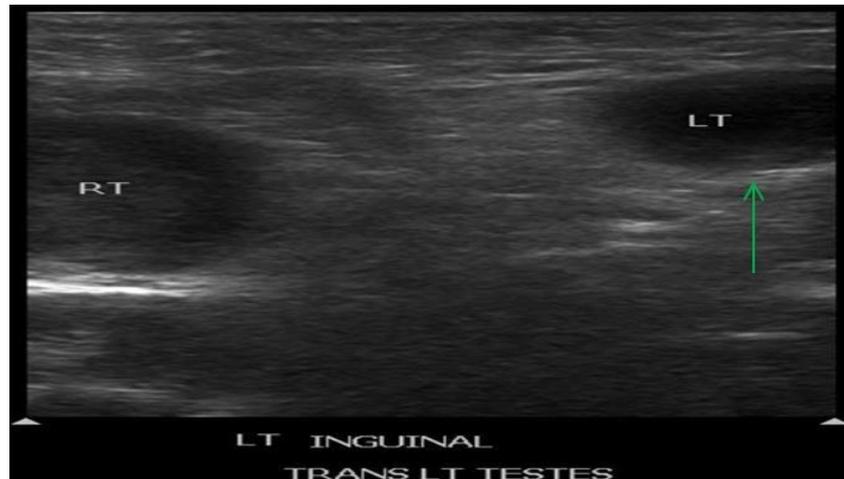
Scrotal ultrasound-transverse view of bilateral testes. There is no left testicle in the scrotum (green arrow). The undescended left testicle was identified in the inguinal canal, measuring 1.7 x 0.9 x 1.0 cm with normal vascular flow. Left epididymis is unremarkable (not included in this image).
